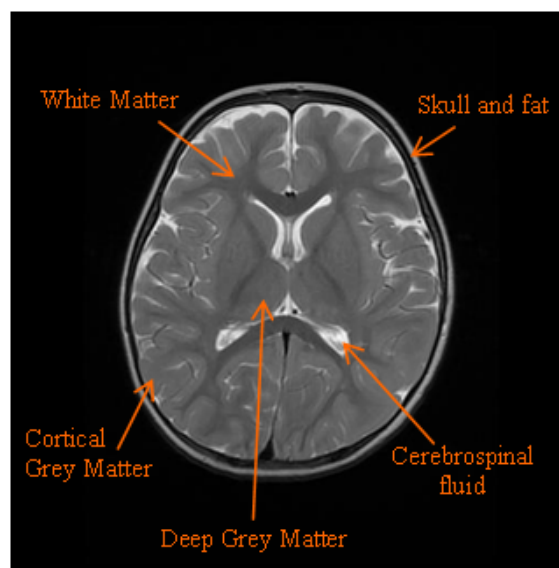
A T2-weighted brain MR image of a two year old child, including the layout of the different brain regions.
